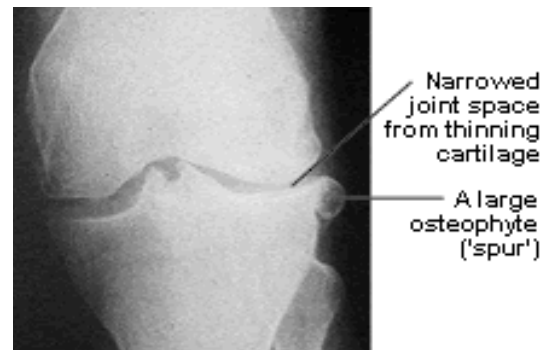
X-ray of the knee joint showing osteoarthritic changes (front view of left leg)
